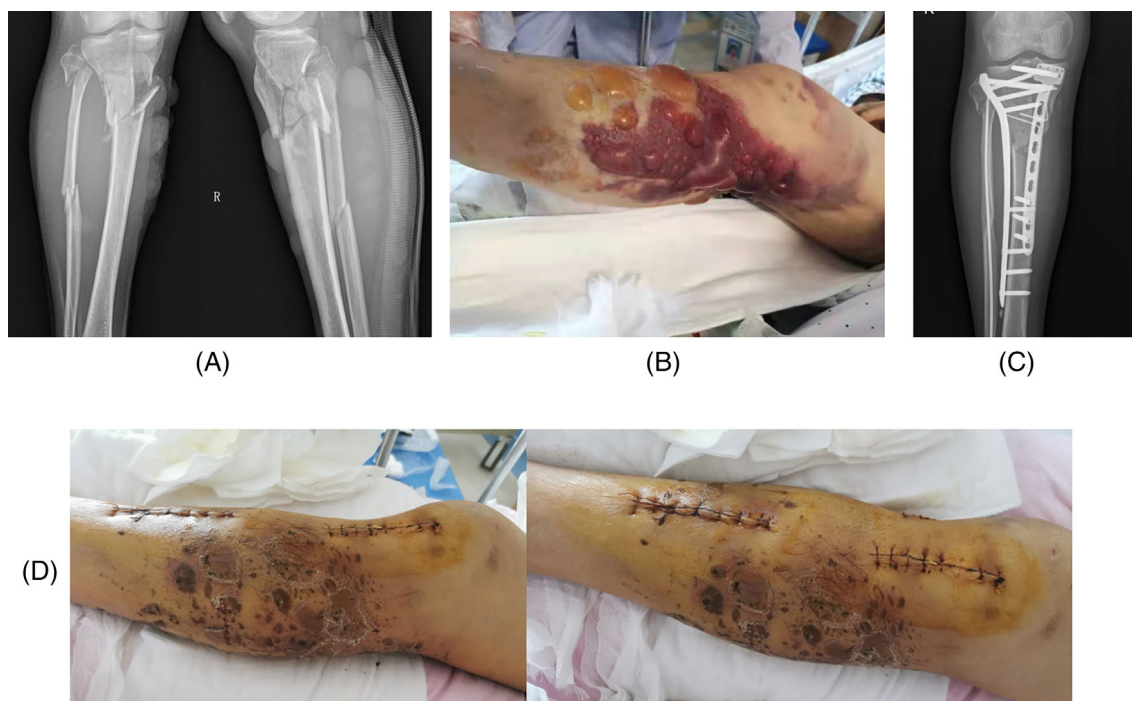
A severe proximal tibia fracture is in severe soft-tissue swelling and a large number of blisters. Waiting for a long time to ORIF, the skin was in good condition after operation. (A) X-ray before operation. (B) Severe soft-tissue swelling and a large number of blisters. (C) X-ray after the operation. (D) Good skin condition after operation. ORIF, open reduction and internal fixation
